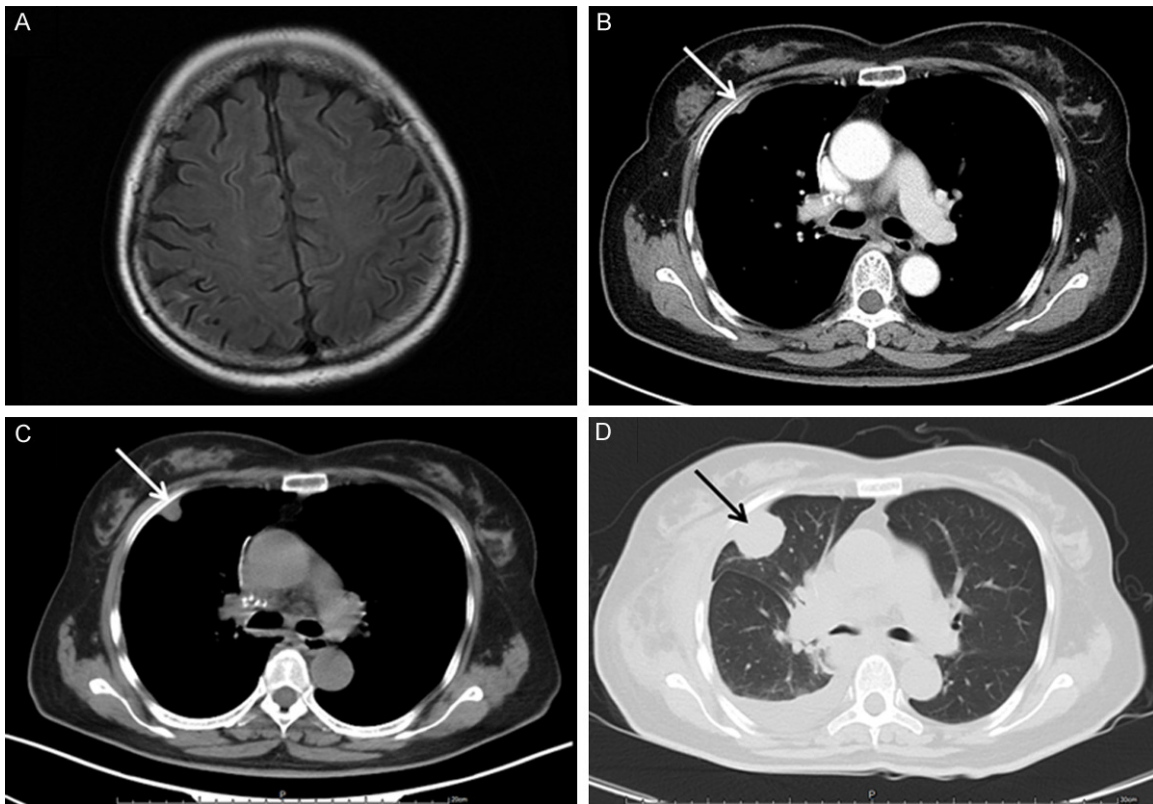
CT scan after radiotherapy combined with chemotherapy. A. Cranial MRI did not show intracranial metastasis. B. Chest CT indicated the right-sided sub-pleural nodules (arrow) had shrunk dramatically. C. Chest CT showed the enlarged right-sided sub-pleural nodules (arrow) after receiving gefitinib treatment for 20 days. D. Chest CT showed the enlarged right-sided subpleural nodules (arrow) after receiving gefitinib treatment for two months.
